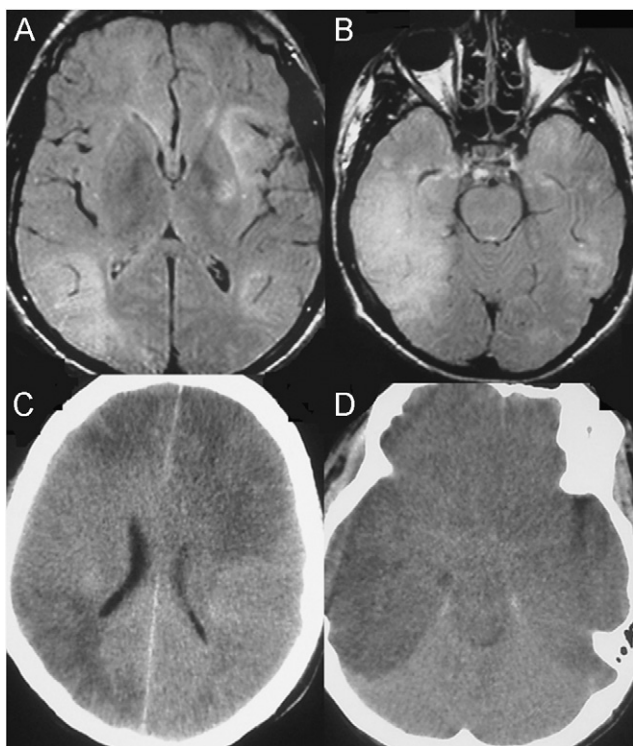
(A and B) Fluid-attenuated inversion-recovery (FLAIR) images performed on day 5 show bilateral cortico-subcortical high signal intensity lesions, with right predominance. The left insula and putamen are involved. (C and D) Brain CT performed on day 32 reveals extensive bilateral hypodensity, and brain edema, with effacement of the basal cisterns and surface sulci.
